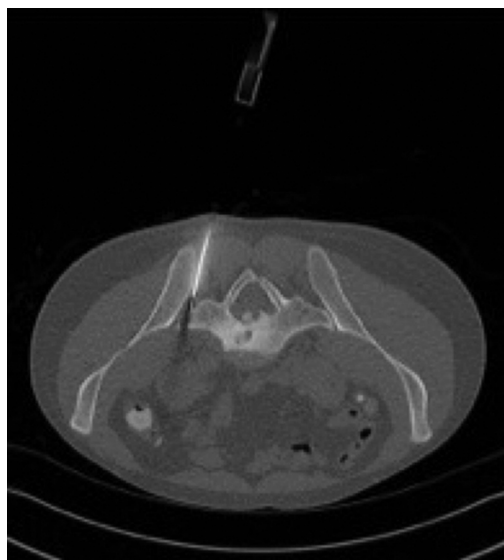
CT-guided biopsy: Axial image shows the trochar and needle tip in a lytic bone lesion of the sacral vertebra.
